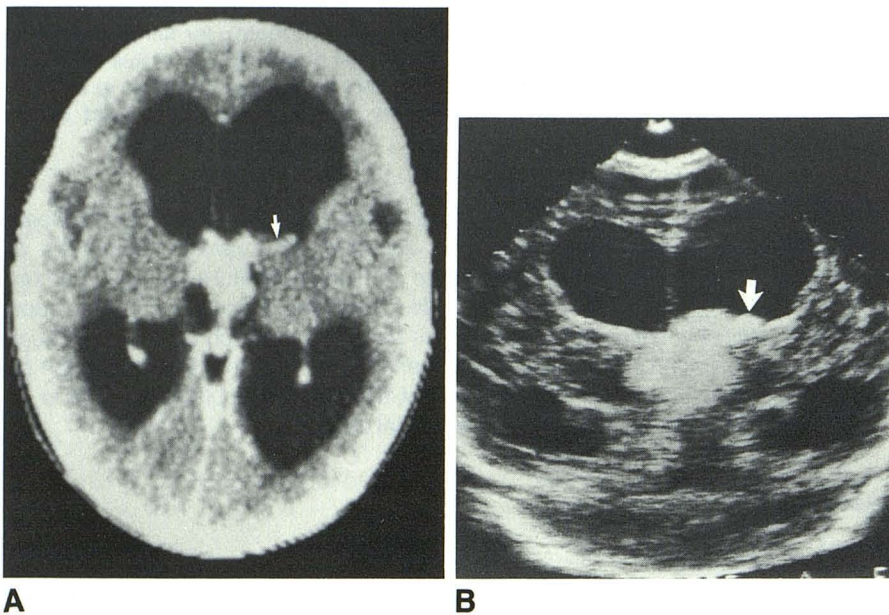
A, Contrast axial CT scan shows a third intraventricular enhancing tumor with extension through left foramen of Monro into body of left lateral ventricle (arrow).
